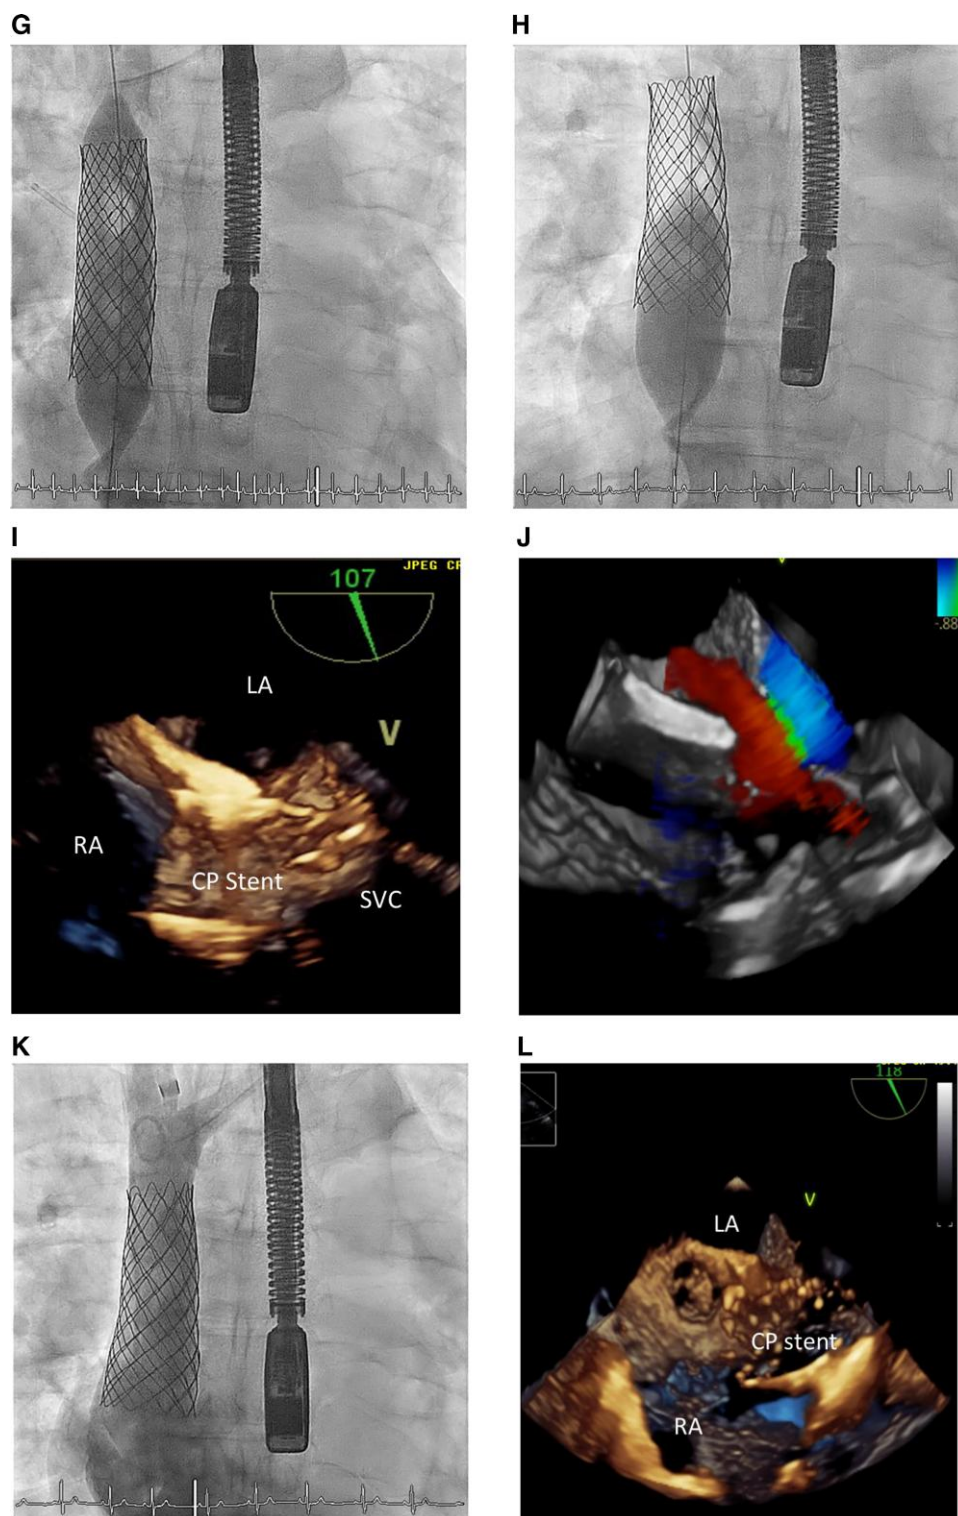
Stepwise modified transcatheter correction of superior sinus venosus atrial septal defect with partial anomalous pulmonary venous drainage of the right upper pulmonary vein and right middle pulmonary vein. (A) Computed tomography scan depicting superior sinus venosus atrial septal defect with partial anomalous drainage of the right upper pulmonary vein and right middle pulmonary vein into the superior vena cava. (B) 3D reconstruction of computed tomography scan images. (C) 3D transoesophageal echocardiography showing dimensions of the superior sinus venosus atrial septal defect (1.2 × 2.0 cm). (D) 3D transoesophageal echocardiography depicting the anatomical conditions between the interatrial junction, superior sinus venosus atrial septal defect and superior vena cava. (E) Induction of a 2-0 Ethicon® surgical silk stitch, which is extracted from RIJ access to allow secure anchoring of the CP stent during balloon expansion. (F) Placement of the custom-made pre-mounted 10-zig/80 mm covered CP stent using a 14-F Check-Flo sheath. (G) Deployment of 10-zig CP stent using a 26 mm BiB® catheter. (H) Flaring of the inferior stent section with a 28 mm/4 cm Z med II balloon. (I) 3D transoesophageal echocardiography confirming adequate apposition of the covered CP stent. (J) 3D transoesophageal echocardiography excluding obstruction of the right pulmonary veins. (K) Venography of the superior vena cava revealing no residual shunt. (L) 3D transoesophageal echocardiography showing adequate position of the CP stent. BiB, balloon in balloon; CP, Cheatham platinum; CT, computed tomography; LA, left atrium; RIJ, right internal jugular vein; RMLP, right middle pulmonary vein; RUPV, right upper pulmonary vein; SVC, superior vena cava; TOE, transoesophageal echocardiography.
